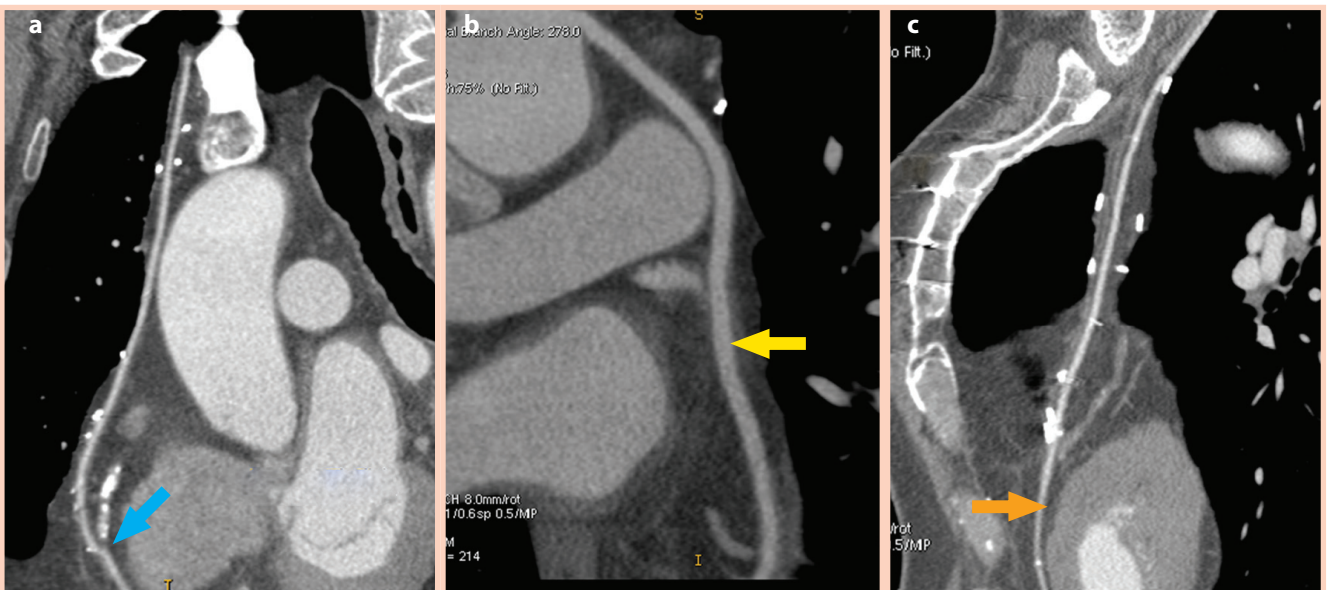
CT of patent grafts of RIMA on RCA (a, blue arrow), venous graft on LCx (b, yellow arrow) and LIMA on LAD (c, orange arrow).
